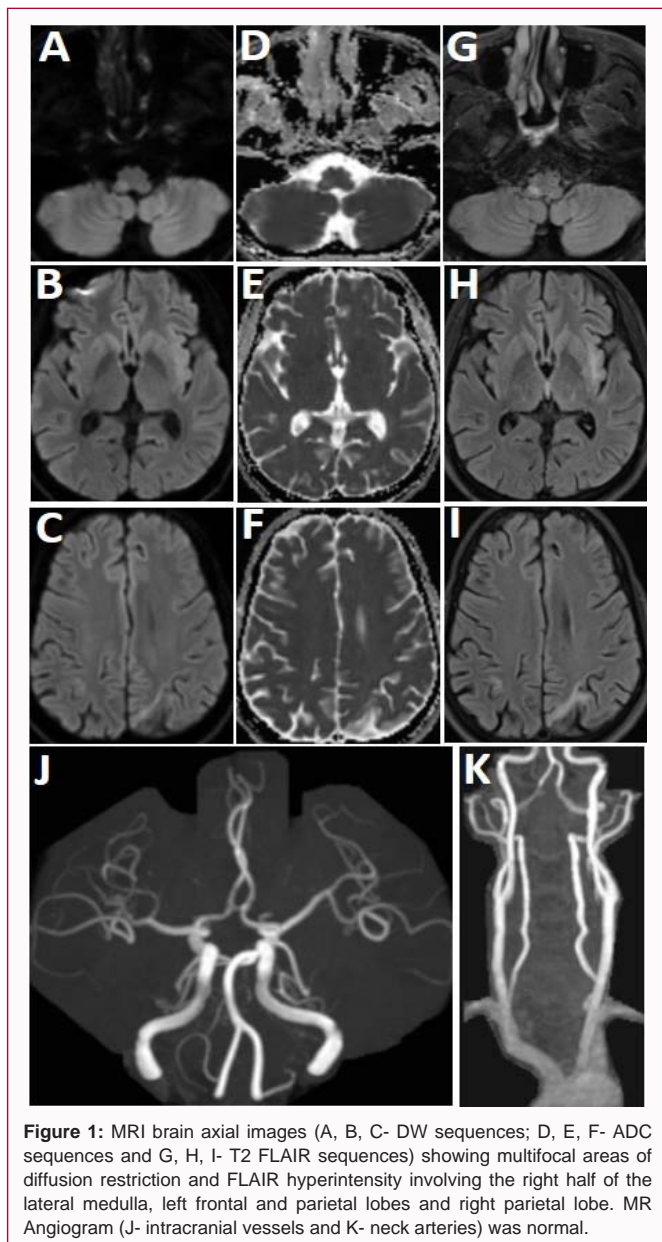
MRI brain axial images (A, B, C- DW sequences; D, E, F- ADC sequences and G, H, I- T2 FLAIR sequences) showing multifocal areas of diffusion restriction and FLAIR hyperintensity involving the right half of the lateral medulla, left frontal and parietal lobes and right parietal lobe. MR Angiogram (J- intracranial vessels and K- neck arteries) was normal.
